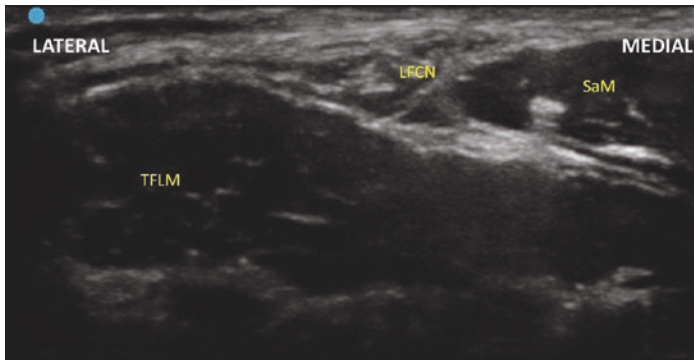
Lateral femoral cutaneous nerve ultrasound. The Lateral Femoral Cutaneous Nerve (LFCN) is located between the tensor fasciae latae muscle (TFLM) and the sartorius muscle (SaM)
